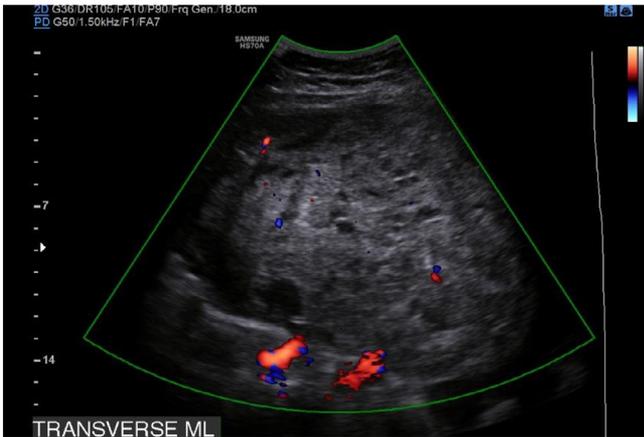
A predominantly solid tumor with scattered cystic changes demonstrates minimal vascular flow—color Doppler score of 2. Surgical diagnosis was a yolk sac tumor of the ovary.
